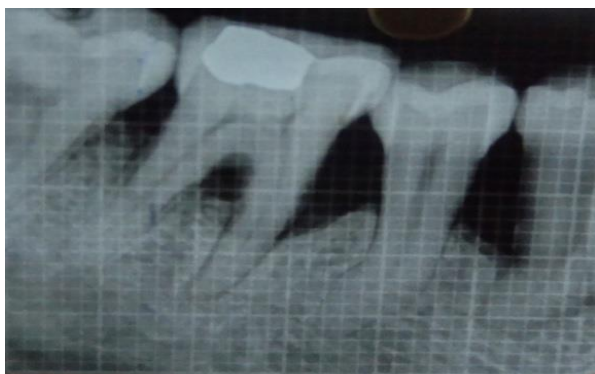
Post -operative radiographic picture of the defect at six months.
